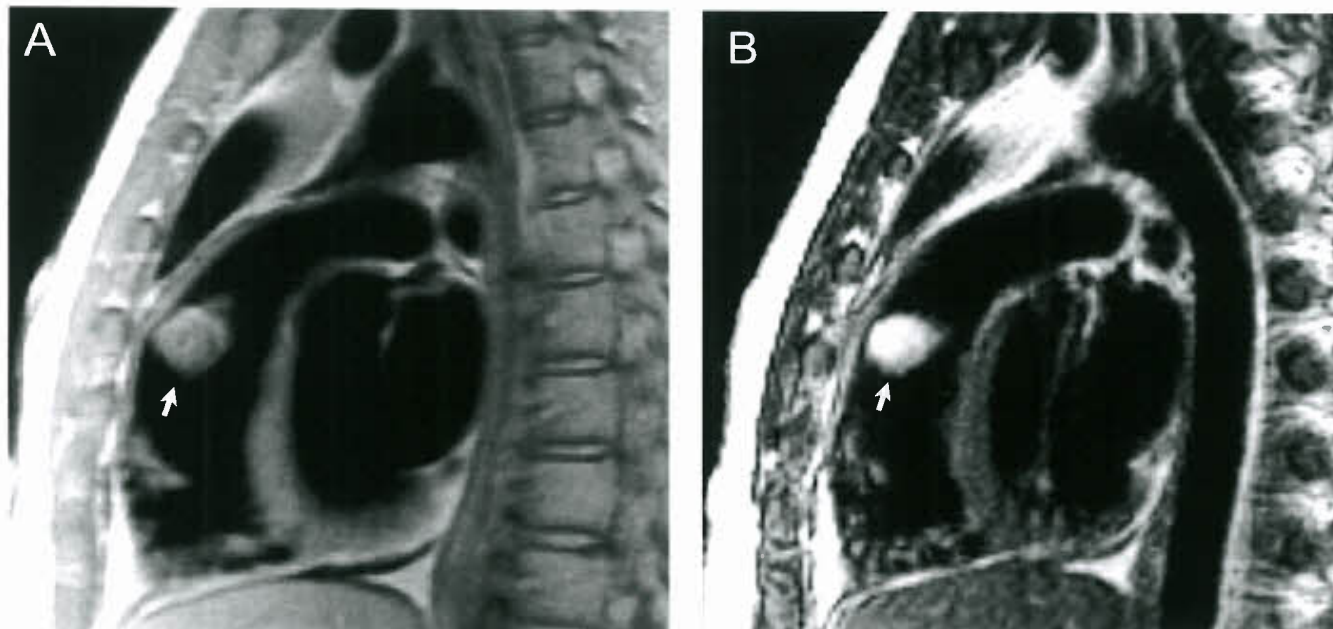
Short-axis FSE image in a patient with hemangioma of the RVOT. A: T1-weighted image showing a slightly hyperintense globular tumor (arrow); B: T2-weighted image showing the tumor is markedly hyperintense, consistent with a vascular tumor.
